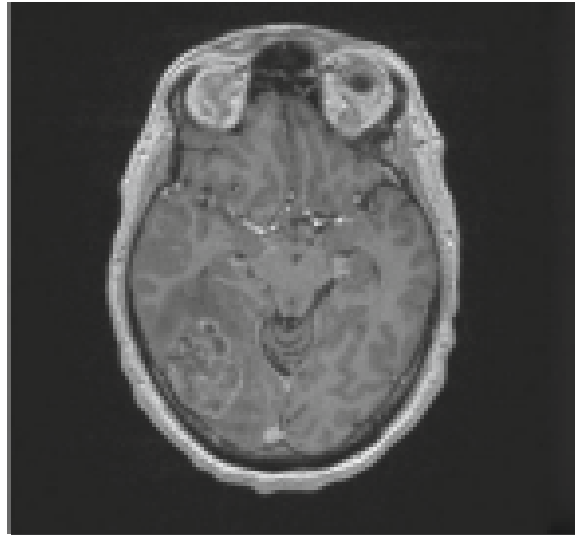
Magnetic Resonance Imaging (MRI) scan of the brain.
